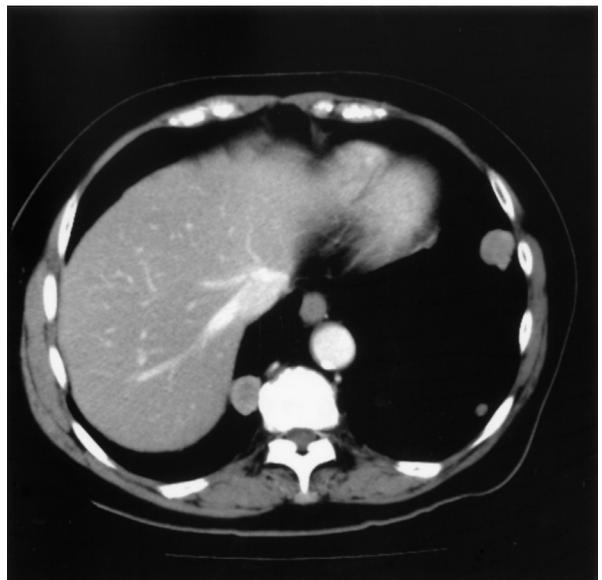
Chest CT confirms multiple intrapulmonary variable-sized tumors.
